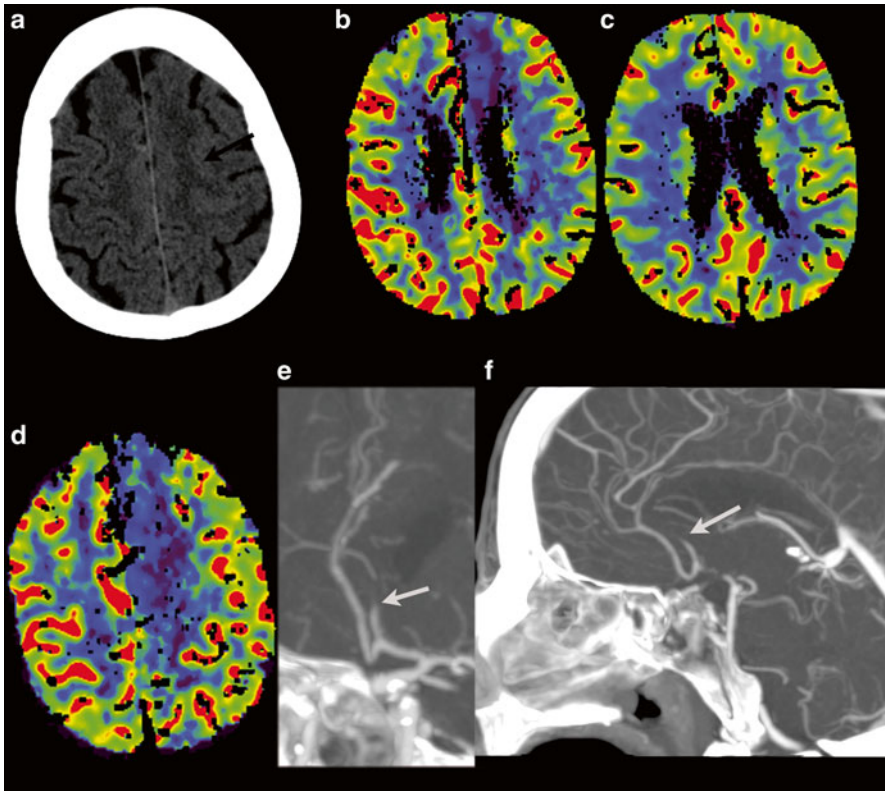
Seventy-two y/o female. Presented with speech disturbances and left-sided motor deficit. NECT shows subtle effacement of the sulci of the left hemisphere (a, *black arrow*). VPCT shows CBF/CBV mismatch (b and c), with reduced flow in the territory of the left anterior cerebral artery (d). CTA shows occlusion of the left A2 segment, *white arrow* (e: oblique MIP, f: lateral MIP), without abnormalities of the other intra- and extracranial vessels. She received i.v. rTPA. Clinical follow-up demonstrated recovery of the paresis with MRC grade 4 of right arm and leg
